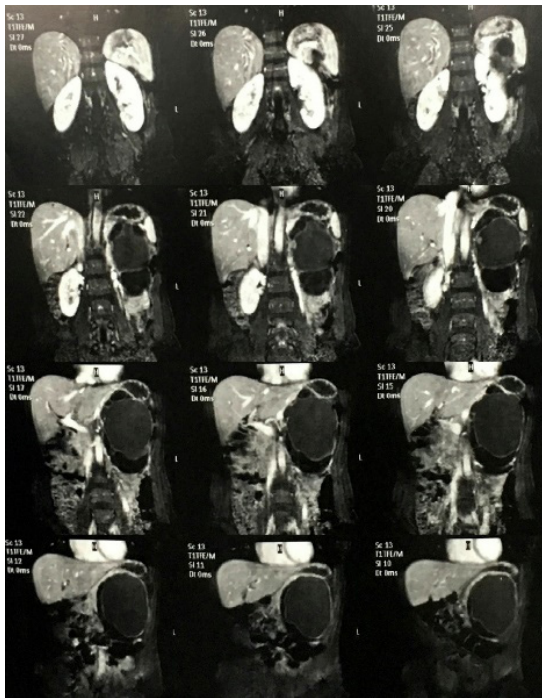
Coronal computed tomography sections of the abdomen suggestive of a cystic neoplastic lesion in close relationship with the body/tail of the pancreas, measuring approximately 13.9 x 11.9 x 10.3 cm (author's personal file, 2019).
